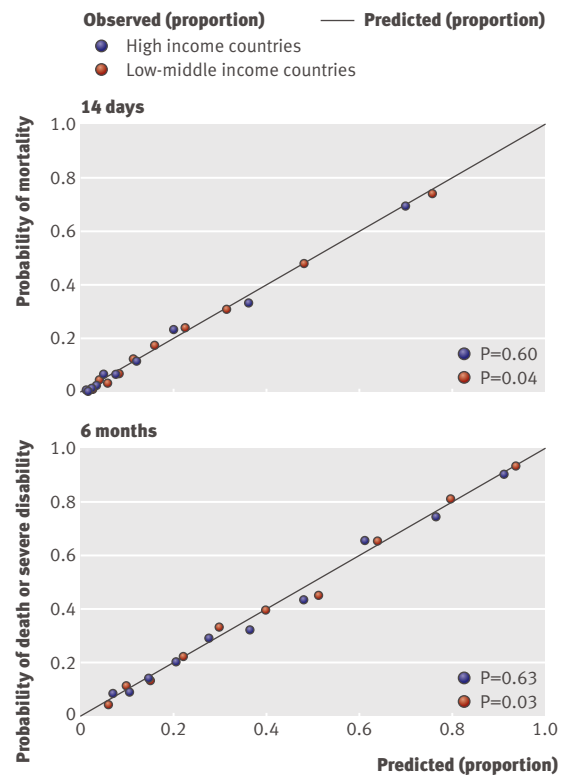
Calibration of computed tomography models using expected and observed probabilities of mortality at 14 days (top) and death or severe disability at six months (bottom) in patient with traumatic brain injury according to income level of country
